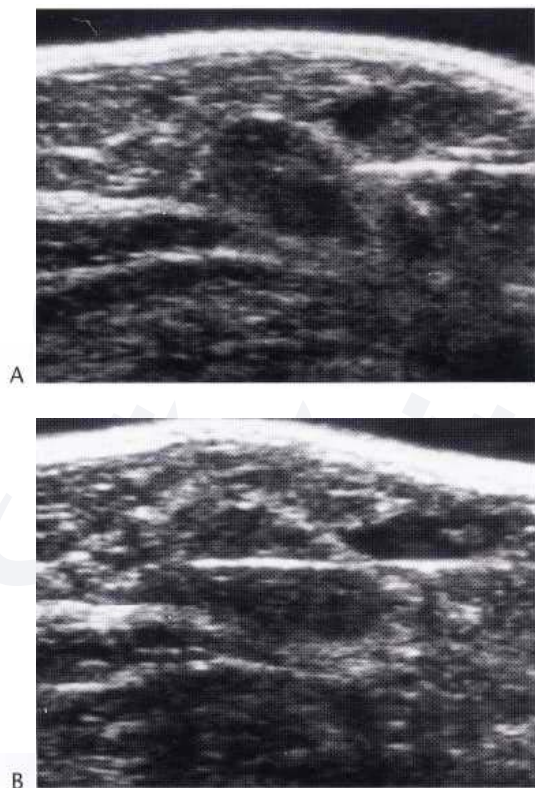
Ultrasound-guided 14G core biopsy of a solid mass. (A) The tip of the needle is positioned just proximal to the lesion prior to firing the biopsy device. (B) The needle is demonstrated within the lesion after firing the biopsy device. Note that the needle is parallel to the chest wall.
